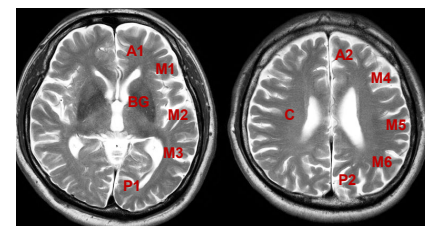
Vascular territories on MRI.
